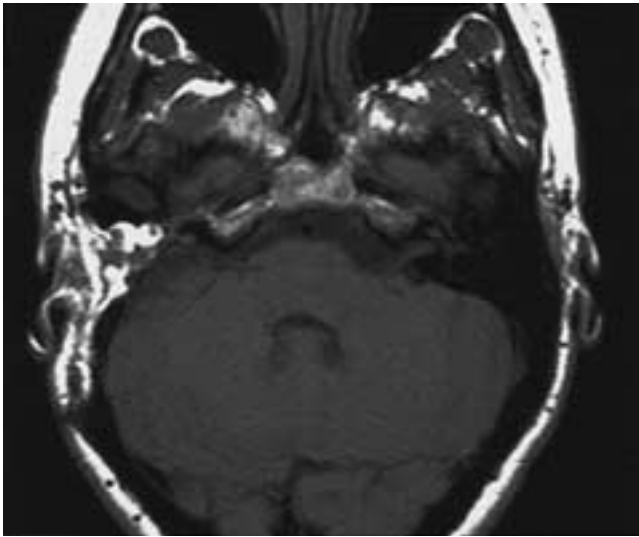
Translabyrinthine approach to the IAC. Axial T1-weighted MR image shows a right canal mastoidectomy with removal of the labyrinth and the posterior wall of the EAC. There is high signal intensity fat packing in the surgical defect.
